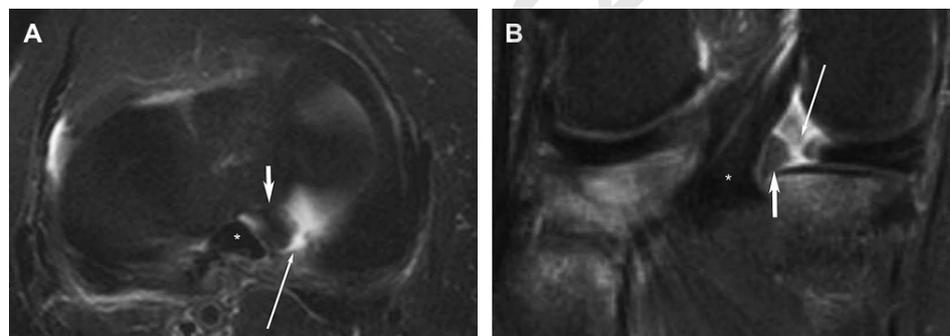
(A) FSE T2-weighted fat-saturated axial image demonstrating a radial tear (thin arrow) of the posterior horn of the medial meniscus near the posterior meniscal root attachment (thick arrow). Note the proximity of the PCL (asterisk) to the posterior root attachment of the posterior horn of the medial meniscus.
